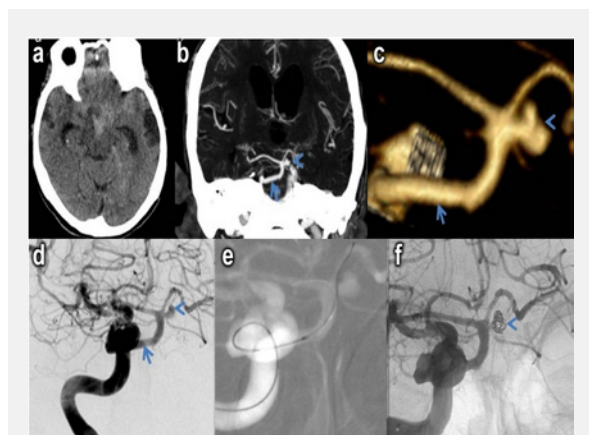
Brain CT scan shows subarachnoid hemorrhage located in the left ambient and quadrigeminal cisterns (a). Brain CT angiography (b,c) and digital subtraction angiography (d) show the persistent primitive trigeminal artery (arrow) originating from the right internal carotid artery, displastic basilar artery and 3,5x4,5x5 mm saccular aneurysm (arrowhead) at the junction of the basilar artery-the left superior cerebellar artery. Final angiograms shows catheterization of the aneurysm through PTA and complete occlusion of the aneurysm after coils placement (e,f).
